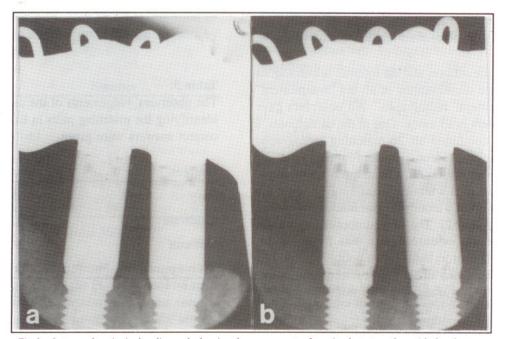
Intra-oral periapical radiograph showing the upper parts of two implants together with the abutments and parts of the superstructure. The radiograph was taken at the time of superstructure placement.
